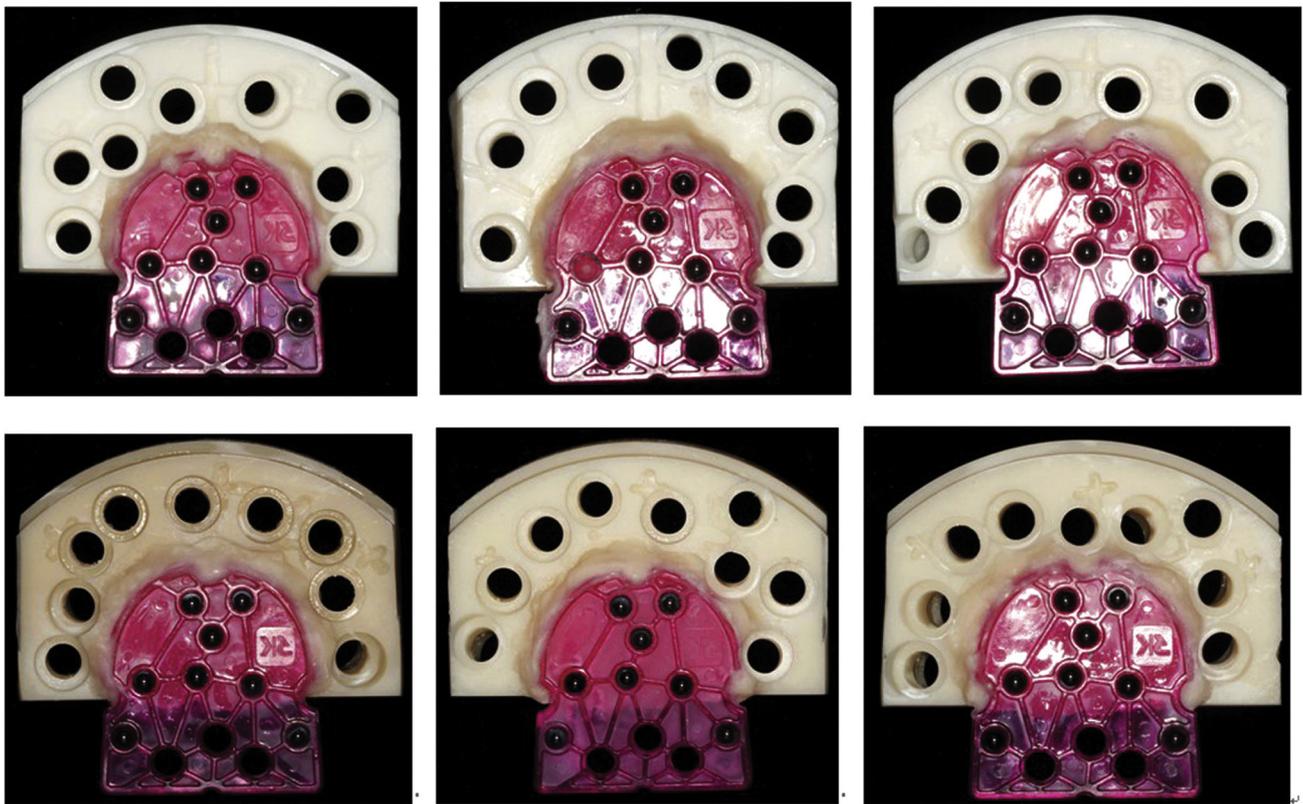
Radiographic guides with diagnostic template bonded on top.
